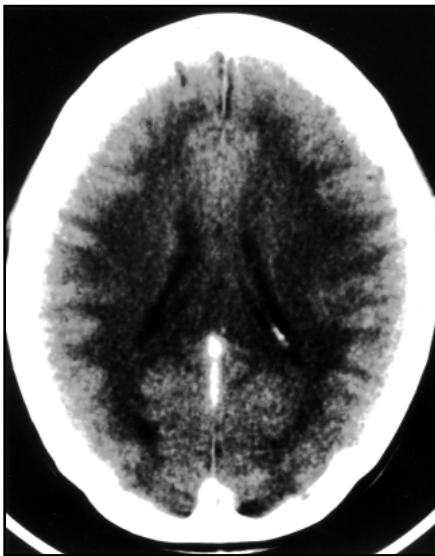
Non-contrasted CT scan demonstrating a hyperdensity in the superior sagittal sinus consistent with thrombosis.
